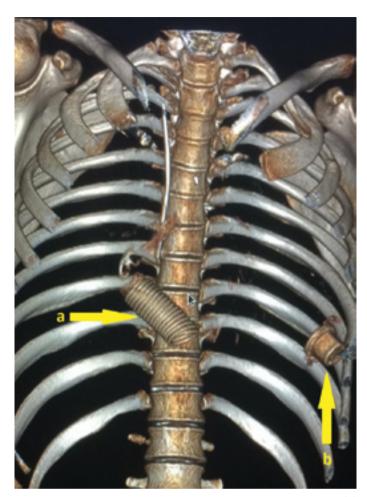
Computed tomography image of retained outflow graft (a) and retained plugged sewing ring of inflow cannula (b) following pump explantation
